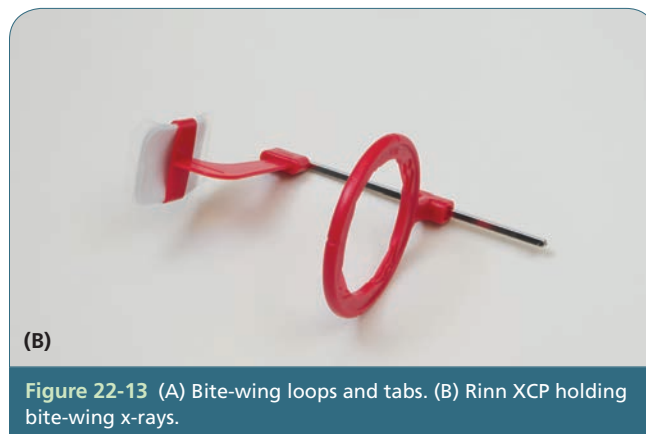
(A) Bite-wing loops and tabs. (B) Rinn XCP holding bite-wing x-rays.
